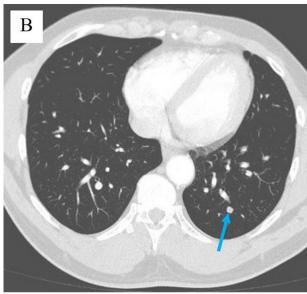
Axial IV contrast-enhanced CT image through the chest shows subcentimeter pulmonary nodules in the right middle lobe and in the left lower lobe (blue arrows).
